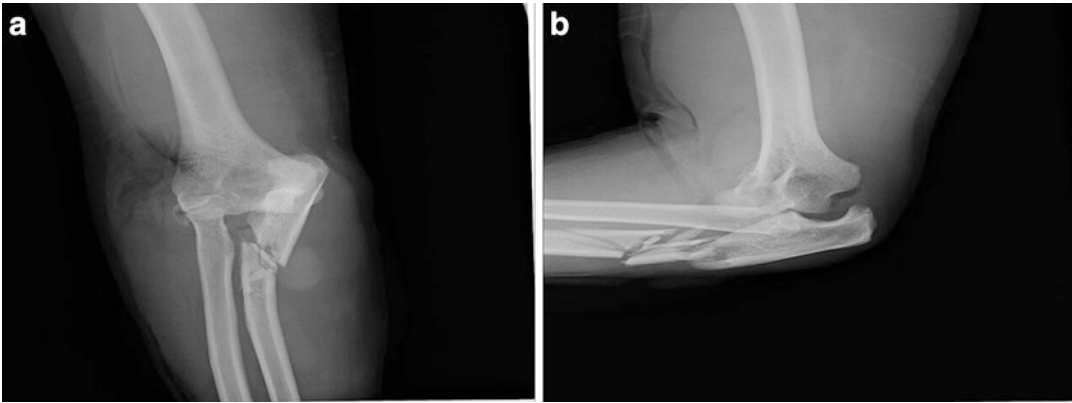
(a) Preoperative AP radiograph of the right elbow. (b) Preoperative lateral radiograph of the right elbow
